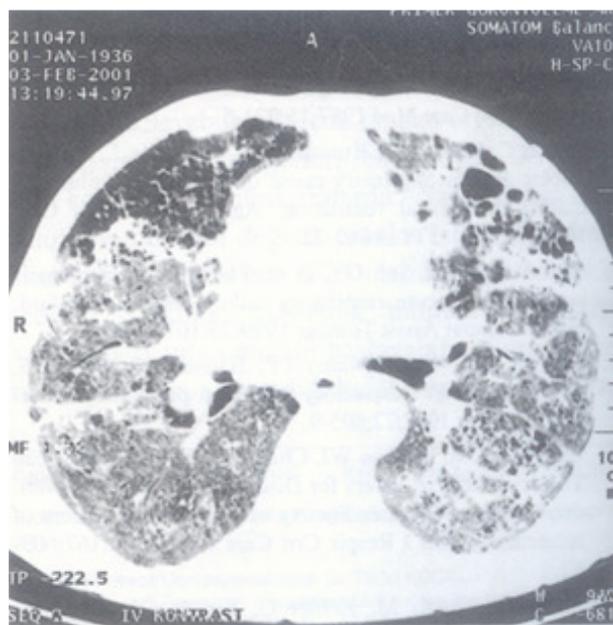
CT of thorax after 2 months of therapy showing interstitial pattern.
